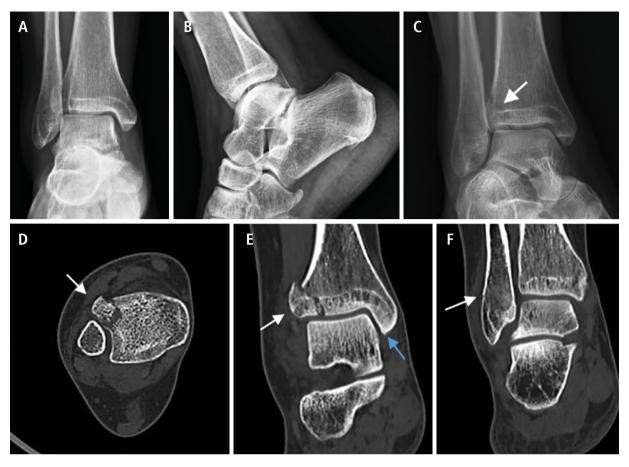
The ankle images of a 38-year-old female patient; A. Anterior-posterior conventional radiography (X-ray) image; B. Lateral X-ray image; C. Ankle stress X-ray image, arrow: tibial plafond fracture (oblique fracture); D. Axial computed tomography (CT) image, arrow: the displaced fracture in tibial plafond; E. Coronal CT image, white arrow: an oblique displaced fracture in tibial plafond that extends into the joint space, blue arrow: an avulsion fracture in the medial malleolus; F. Coronal CT image, arrow: an oblique fracture in the lateral malleolus
